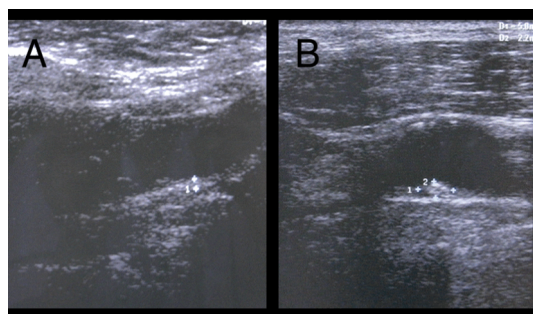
(A and B) Carotid ultrasound (Siemens Acuson X300, 7 MHz linear probe) in a SLE patient: plaques.
